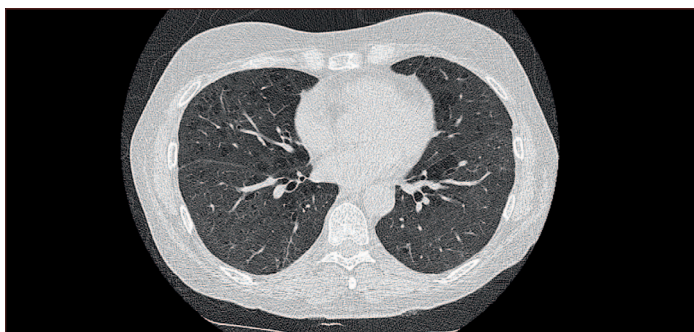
A 58-year-old female presenting with exertional dyspnoea, pleuritic chest pain and cough due to niraparib-induced pneumonitis. High-resolution computed tomography taken 5 months after admission and showing almost complete resolution of ground-glass changes and airway dilatation in the lower zones.
